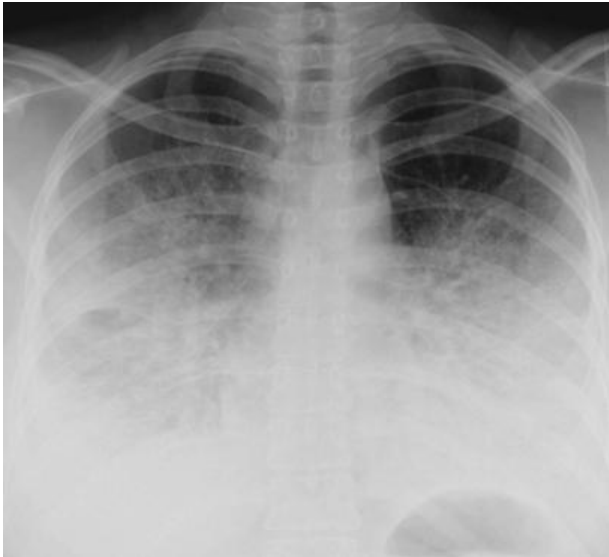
Portable chest radiograph obtained following the onset of cardiopulmonary collapse during cesarean section, demonstrating diffuse bilateral pulmonary infiltrates consistent with acute pulmonary edema in a patient with suspected amniotic fluid embolism.
